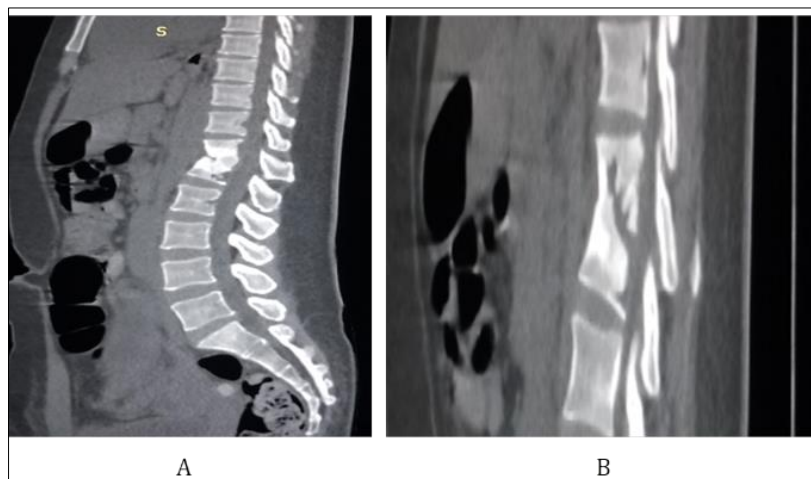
is vertebral window of the sagittal reformatted CT scan showing the levels of the affected vertebrae (T12 and L1). It showed anterior wedged collapse of the aforementioned vertebrae with gibbus deformity Figure 5b is a close-up view.
